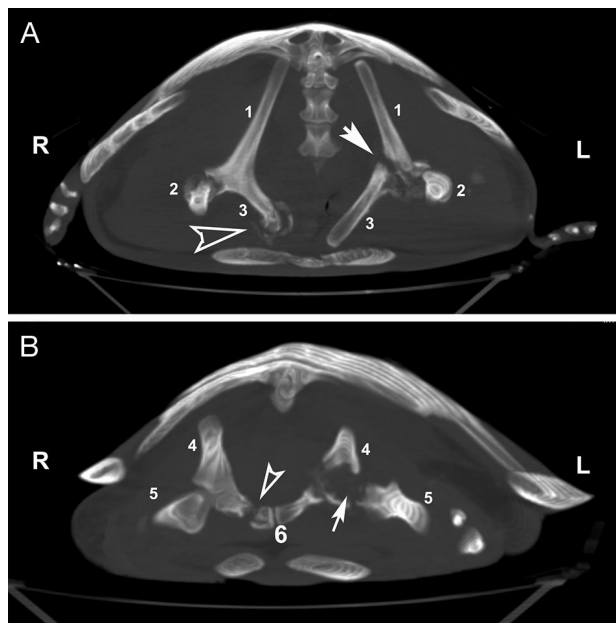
Computed tomography maximum intensity projection (MIP) reconstruction of the (A) pectoral and (B) pelvic girdle. Note that in (A) there are bone lyses and a pathologic fracture with a small callus of the right acromion process (empty arrowhead), and of the insertion of the scapula of the left acromion process (white arrowhead). In (B) there are bone lyses of the left femoral head and acetabulum (white arrow) and a fractured right ischium (empty arrowhead). R: right body side; L: left body side; 1: scapula; 2: insertion of the coracoid to the still unfused scapula; 3: acromion process; 4: ileum; 5: femur; 6: ischium
